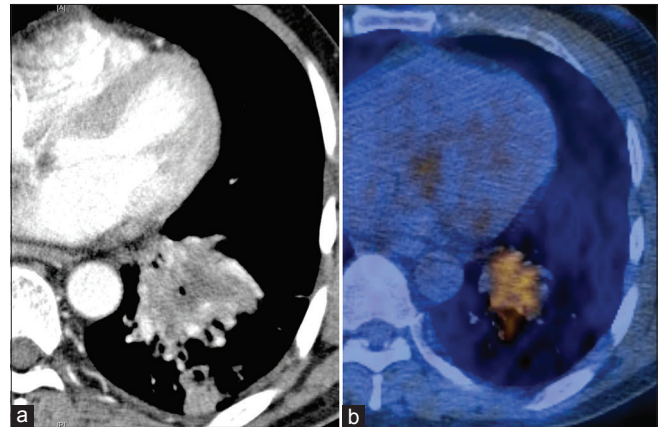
A 59-year-old male with pulmonary actinomycosis. (a) Chest computed tomography scan shows consolidation with necrotic low-attenuation area. (b) positron emission tomography-computed tomography scan shows high metabolic uptake in lesion (maximal standardized uptake value 4.2)
